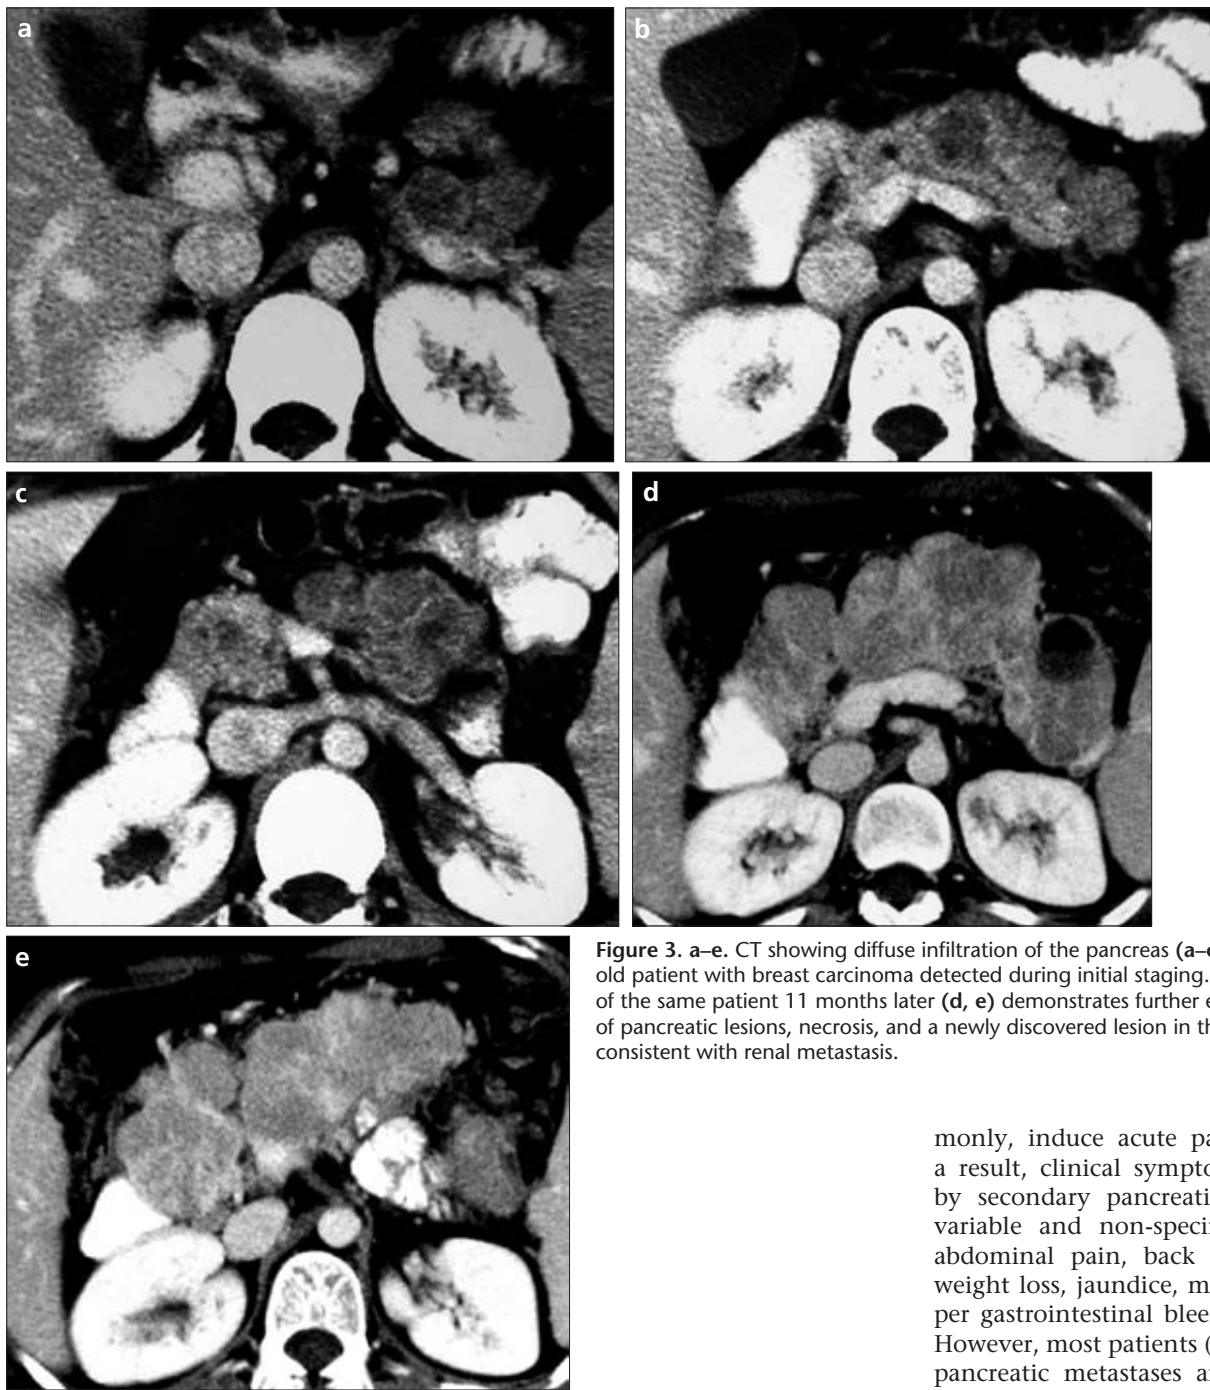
a–e. CT showing diffuse infiltration of the pancreas (a–c) in a 27-year-old patient with breast carcinoma detected during initial staging. Follow-up CT of the same patient 11 months later (d, e) demonstrates further enlargement of pancreatic lesions, necrosis, and a newly discovered lesion in the left kidney consistent with renal metastasis.
